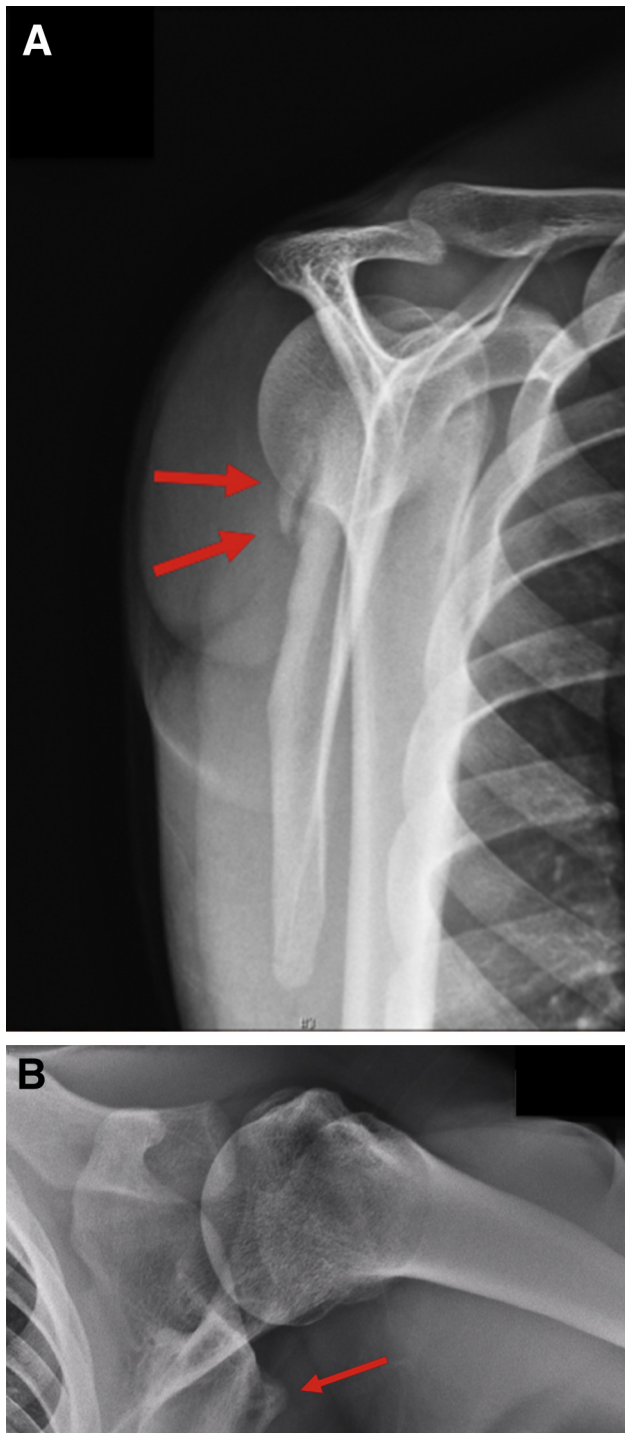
Radiographic images of a Bennett lesion in the left shoulder of a high school pitcher. (A) Lateral view of Bennett lesion in posteroinferior region of glenoid (arrows). (B) An axillary view reveals the posterior exostosis (arrow).
